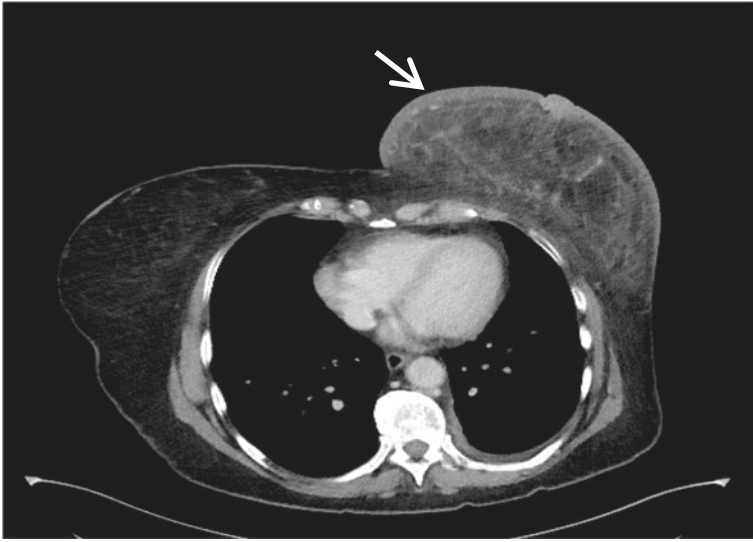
A 45 year-old female presented with left breast pain and swelling. Mammogram and CT TAP were performed. Contrast enhanced axial CT image of the mid-thorax demonstrating an abnormal left breast and diffuse tumour infiltration. The skin is thickened (Arrow) and there is ill-defined increased density, compatible with oedema, without a focal breast mass
